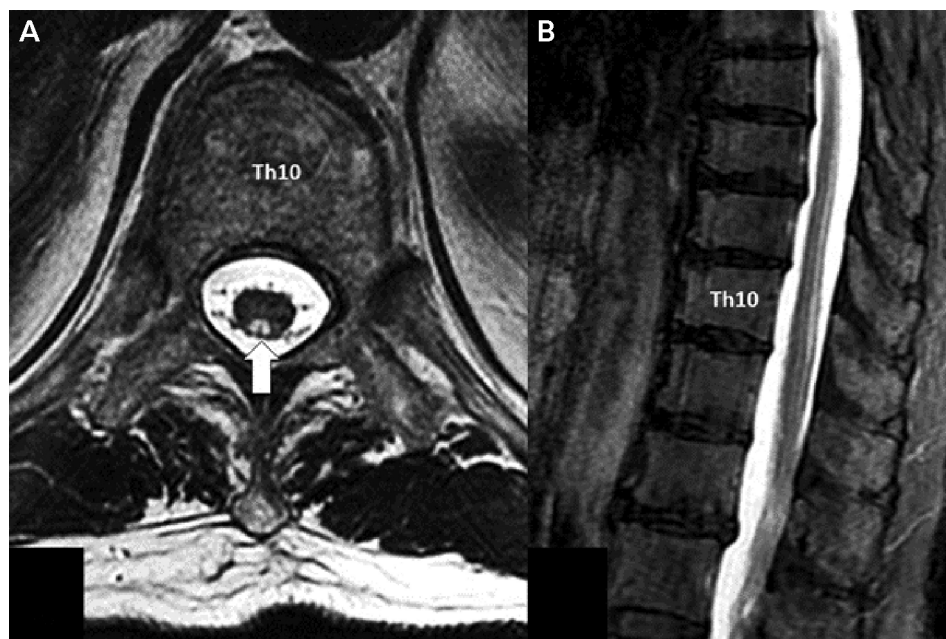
Subacute combined degeneration due to vitamin B₁₂ deficiency. Axial (A) and sagittal (B) T2-weighted images of the spinal cord show hyperintensity in the posterior columns affecting the thoracic spinal cord on sagittal image (B), with an inverted V appearance on axial image (A, arrow).
